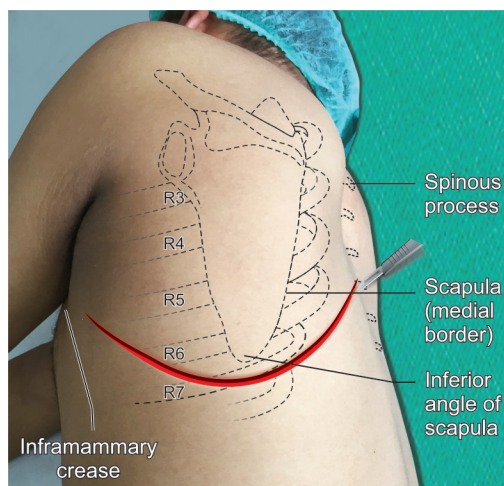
Dorsal spine: Transthoracic approach
